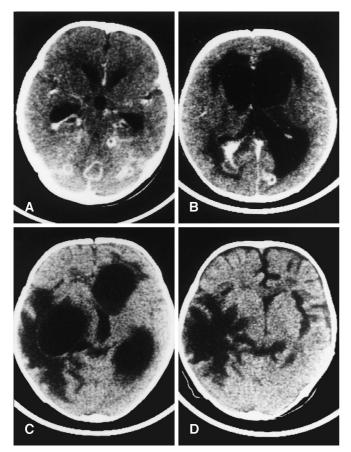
Serial changes on CT. A Enhanced CT on 9 April 1993. Note hydrocephalic changes and multiple ring-enhancement lesions in occipital lobe and ventricular wall. B Enhanced CT on 12 May 1993. Tuberculoma adjacent to the lateral ventricle seems to interrupt CSF flow, thus causing marked hydrocephalus and periventricular edema. C CT on 7 June 1993. Periventricular edema increased after extraction of the drainage. D CT on 8 July 1993. Following VP shunt operation, ventricular dilatation improved, but periventricular edema persisted
